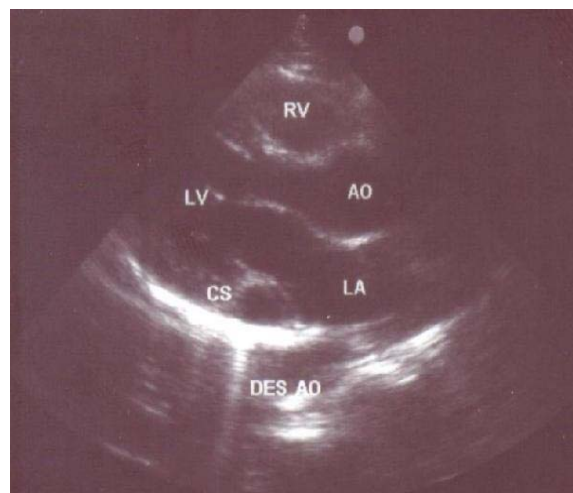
Parasternal long axis two-dimensional echocardiographic view showing dilated coronary sinus. (LA = left atrium, LV = left ventricle, RV= right ventricle, CS = coronary sinus, AO= aorta, DES AO= descending aorta).
